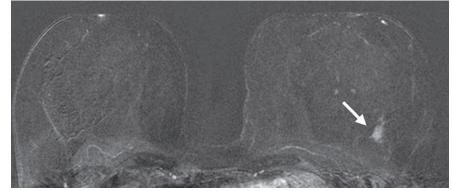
Image in a 55-year-old screening participant. MR-guided biopsy enabled researchers to confirm the presence of an invasive high-grade triple-negative cancer (no special type [NST], pT1b, N0, MO). Breast MR image shows a suspicious enhancing mass (arrow) in the left breast (BI-RADS category 5). (Radiology 2017;283;2:InPress) © RSNA 2017. All rights reserved. Printed with permission.
